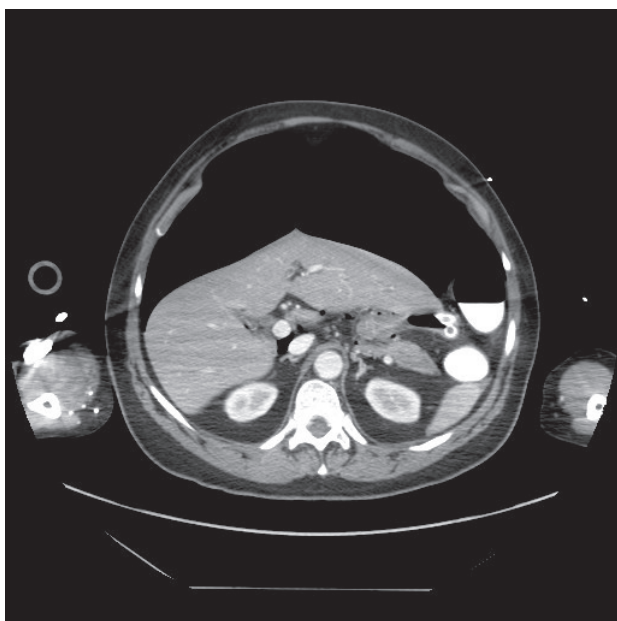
Transverse image of CT abdomen: massive dilatation of the abdomen and pneumoperitoneum. No apparent free fluid, no perforation or contrast extravasation of the stomach could be detected.
